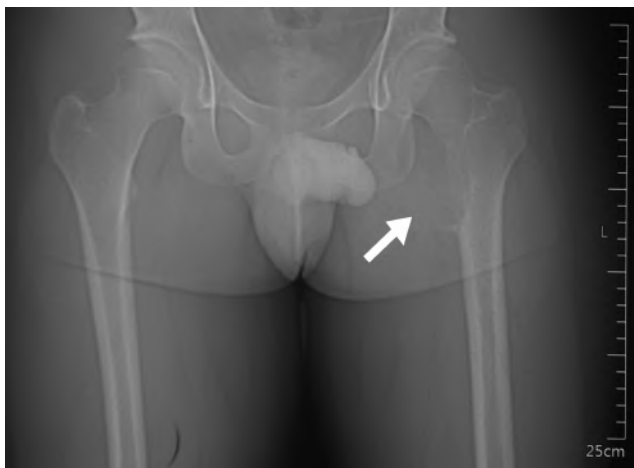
Radiograph of pelvis with both hips anteroposterior view shows an eccentric expansile lytic lesion marked with white arrow in the proximal femoral metaphysis of lesser trochanter left hip
